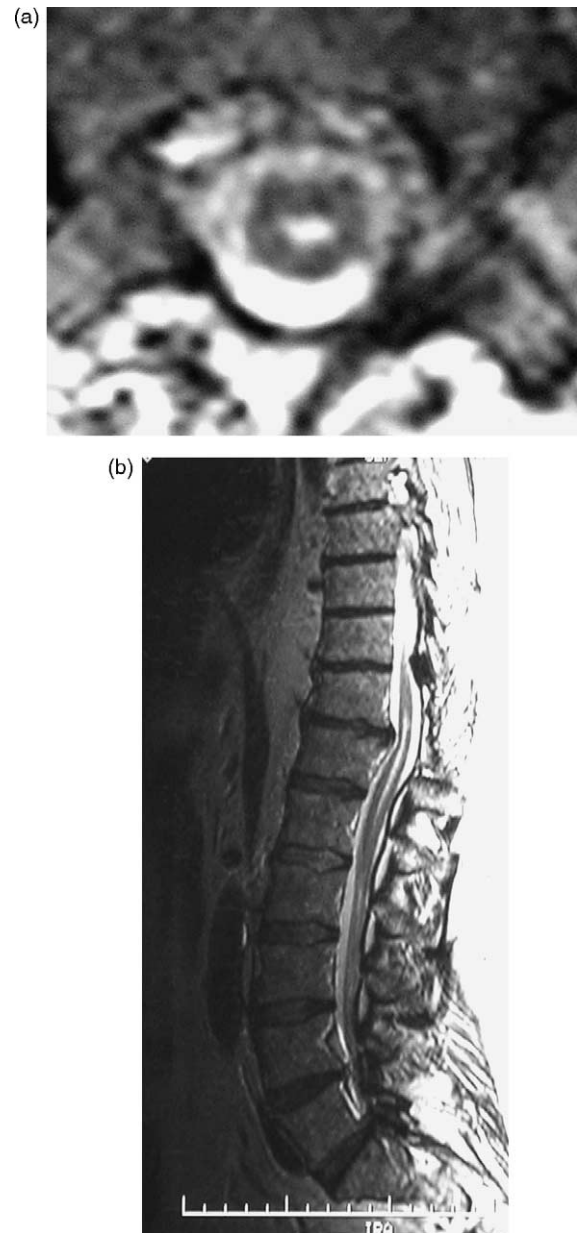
Case 2. T2-weighted axial (a) and sagittal (b) MRI scans of the spinal cord showing a syringomielic cavity between D11 and L1 concurrently with an intervertebral diskal hernia between D11 and D12.
